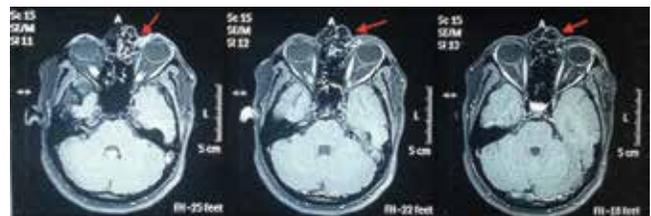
Pre-op MRI scans showing the mass involving left medial orbit and lateral wall of nose.
